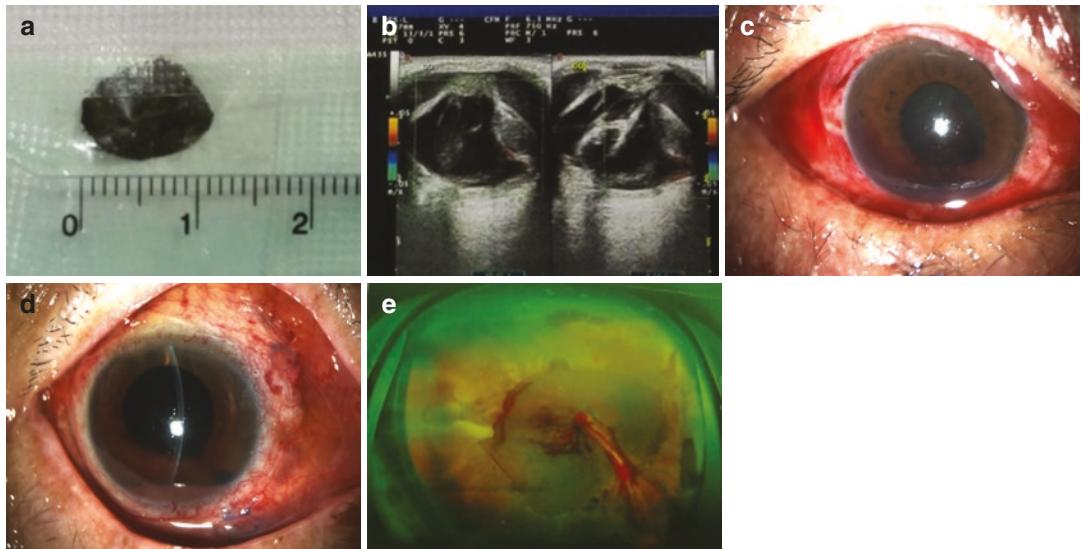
(a) The removed metallic foreign body (size $12 \times 9 \times 3$ mm). (b) Ocular ultrasound showing a V-shape membrane attached to the optic nerve head, indicative of a total retinal detachment and choroidal detachment. (c) The appearance of the eye after scleral debridement and suture
